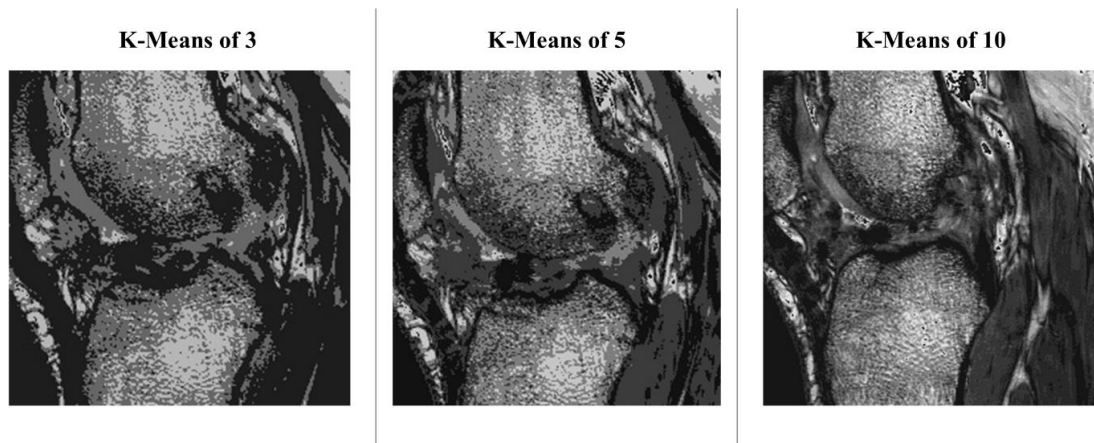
K-means relabeling of an MR image using k of 3, 5, and 10.
